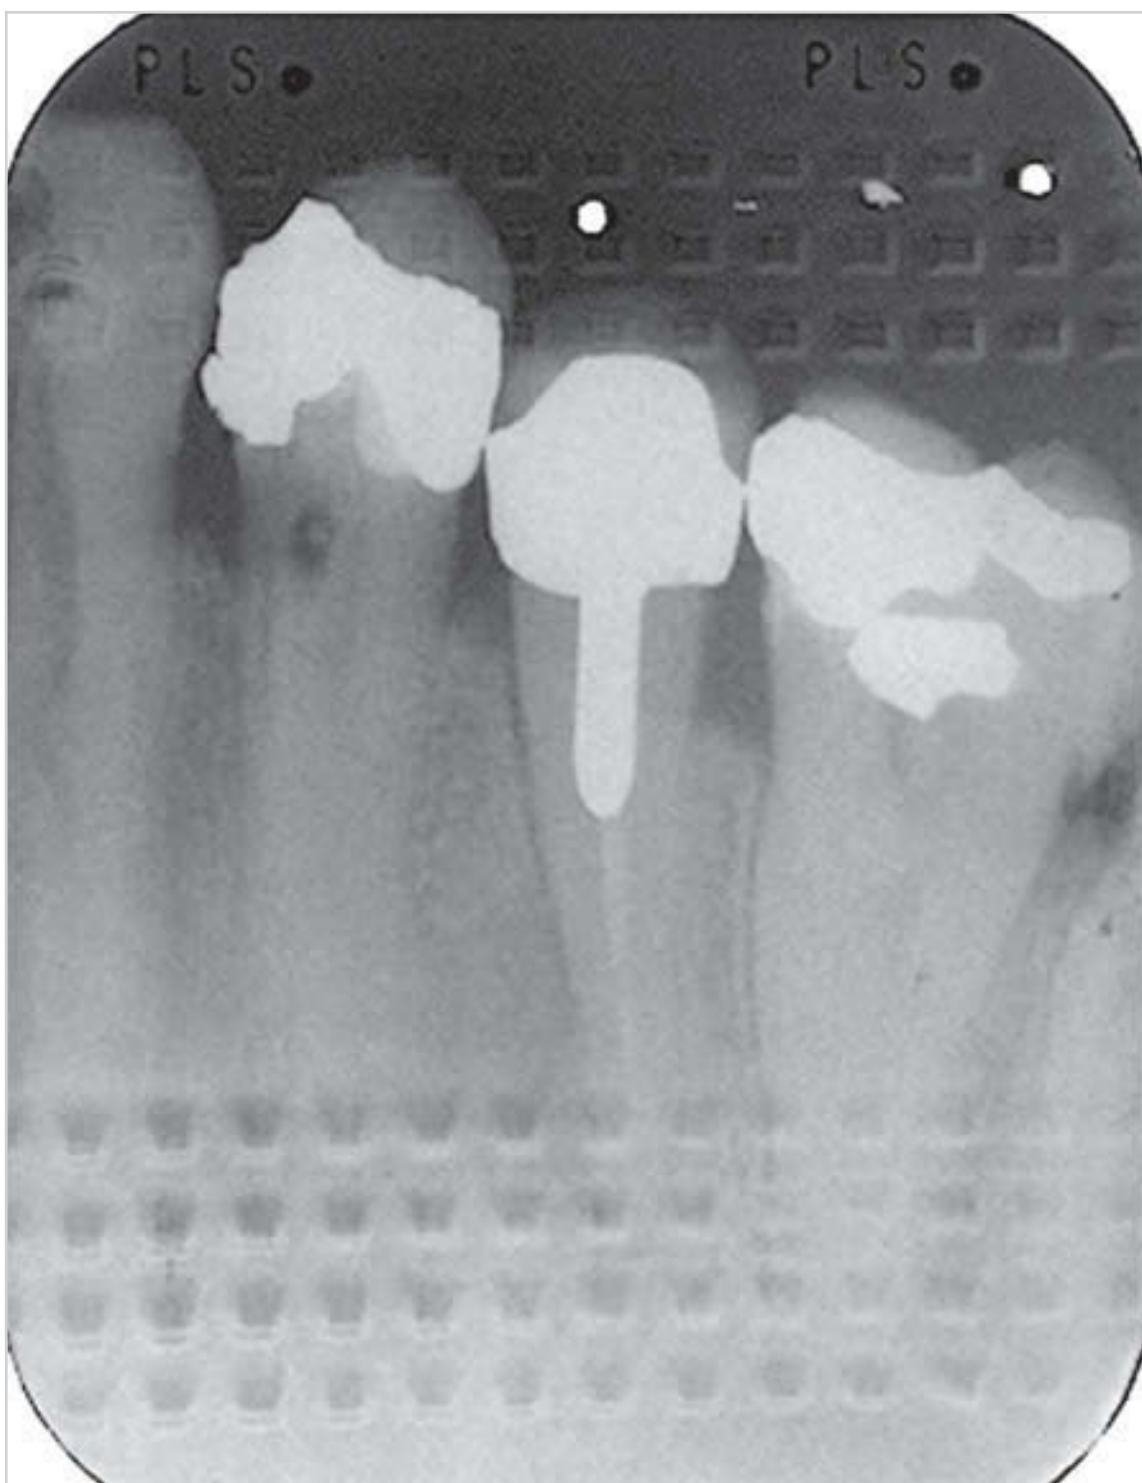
If X-ray film is exposed on the wrong side, the pattern embossed on the lead foil can be seen.
